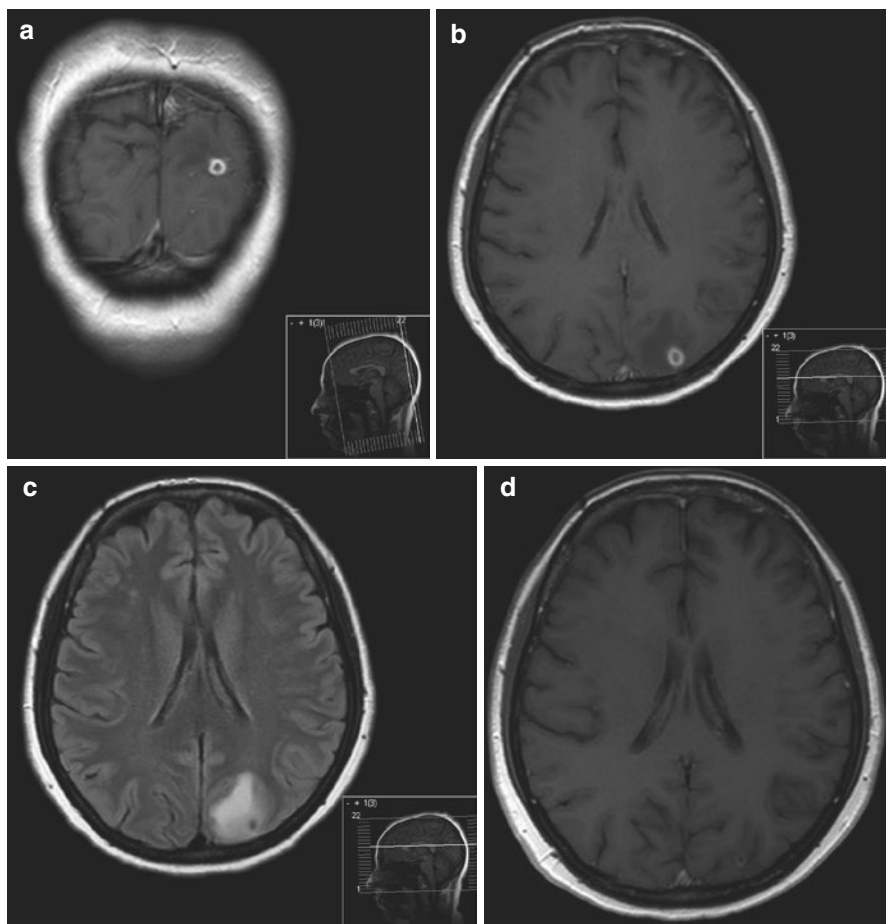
(a, b) T1 weighted MRI showing left sided ring enhancing lesion within the occipital cortex, (c) axial T2 weighted MRI showing edema around the lesion, and (d) T1 weighted MRI showing reduction in the lesion following treatment
